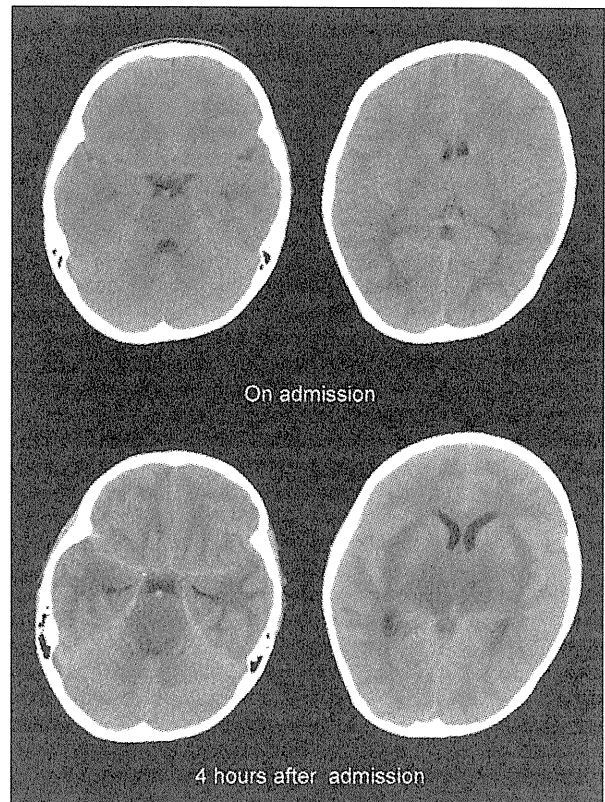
Head CT findings (Patient 2). (Top) The head CT on admission shows mild low-density lesions in the brainstem (left), mild blurring of the gray–white matter junction, and mild narrowing of the extra-axial spaces, suggesting mild brain edema (right). (Bottom) The head CT 4 h after admission shows marked low-density lesions and swelling in the brainstem (left), evident blurring of the gray–white matter junction, and marked low densities in the bilateral thalami (right). Narrowing of the extra-axial spaces and fourth ventricle are also seen.
